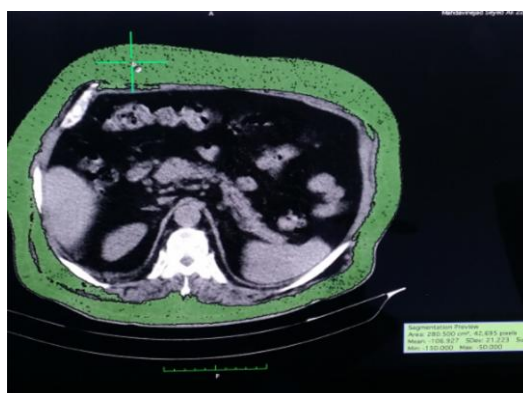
The CT scan of the patient showing the lowest amount of visceral fat.
